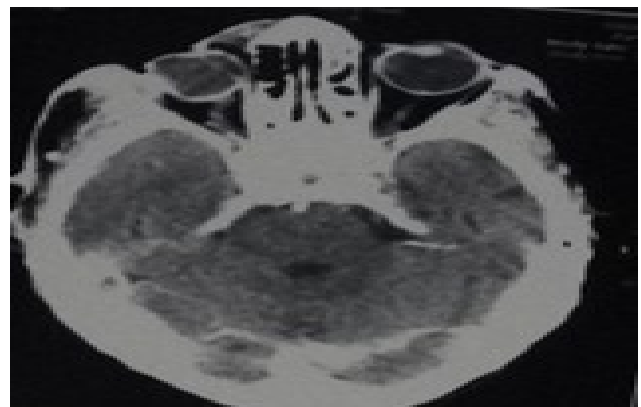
Axial view of skull computed tomography. The right globe is deformed, and the optic nerve is distended, compared to left globe.
